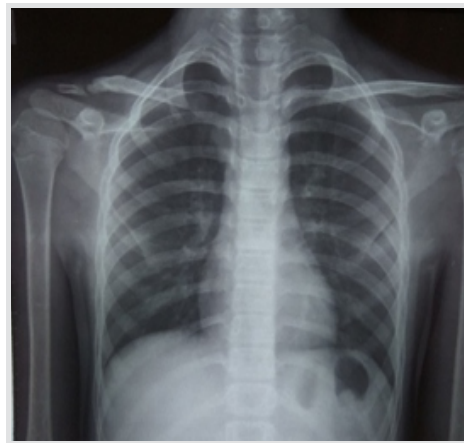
Five-month post-operative X-ray showing regeneration of the bone within the intact periosteum.
